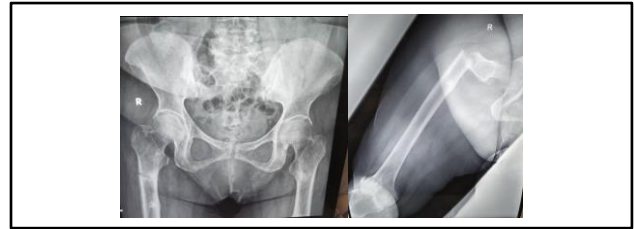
Pelvic x-ray showing looser zone
